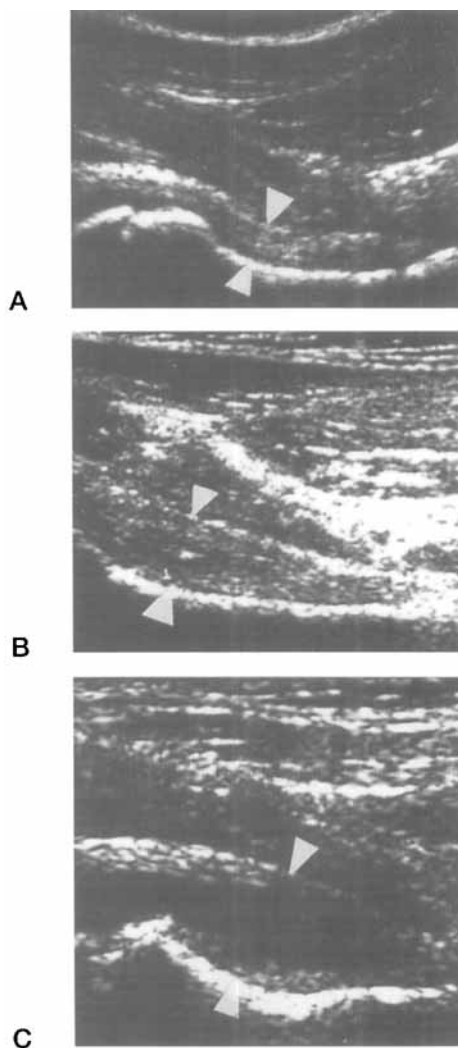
Ultrasonographic hip scans with arrowheads indicating the points used for measurements: A. normal (boy, 9 years, synovial capsular complex distance 6.0 mm), B. synovial swelling (girl, 8 years, distance 7.9 mm), and C. synovial swelling with effusion (boy, 4 years, distance 10.8 mm).
